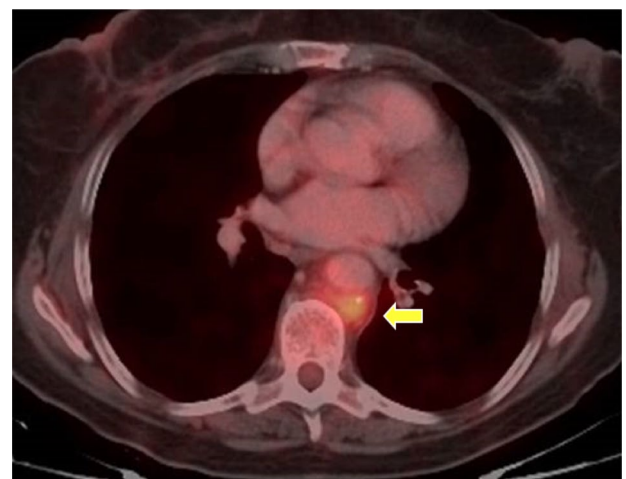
PET-CT scan depicts uptake in the posterior wall of the aorta due to MAA (arrowed). PET-CT indicates positron emission tomography-computed tomography.
